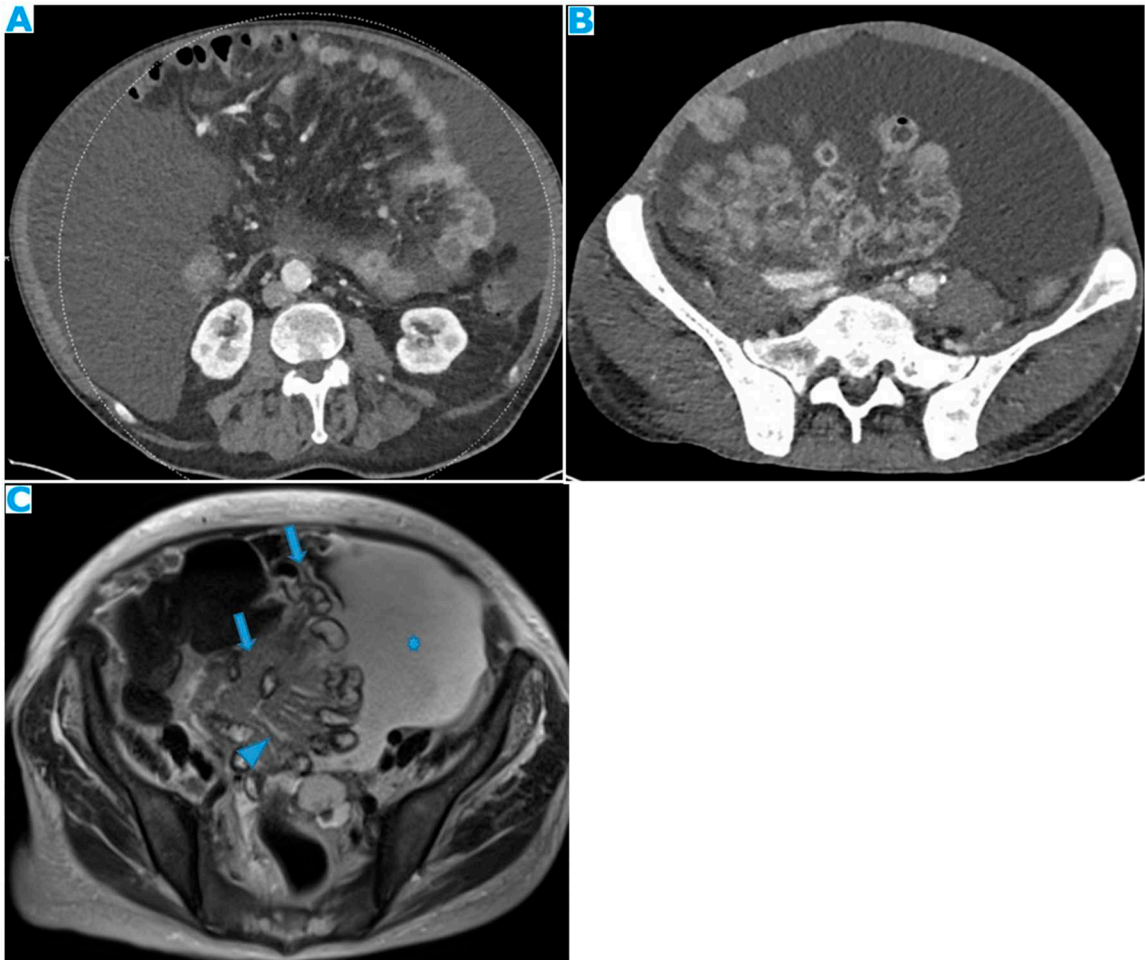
Axial CE-CT (A, B). A : non-malignant ascites, B : malignant ascites from colon adenocarcinoma. Observe how SB loops float freely on A, with an anterior disposition. On a malignant ascites (B), SB loops are drawn posteriorly and lose contact with the anterior abdominal wall (tethered-bowel sign) due to the rigid infiltrated mesenteric leaves. Axial T2WI (C). PC from endometrial carcinoma: Diffuse mesenteric deposit seeding (arrow) which causes SB retraction (tethered-bowel sign). Notice that despite massive ascites (*), there is scarce quantity of liquid between the rigid infiltrated mesenteric leaves (arrowhead).
